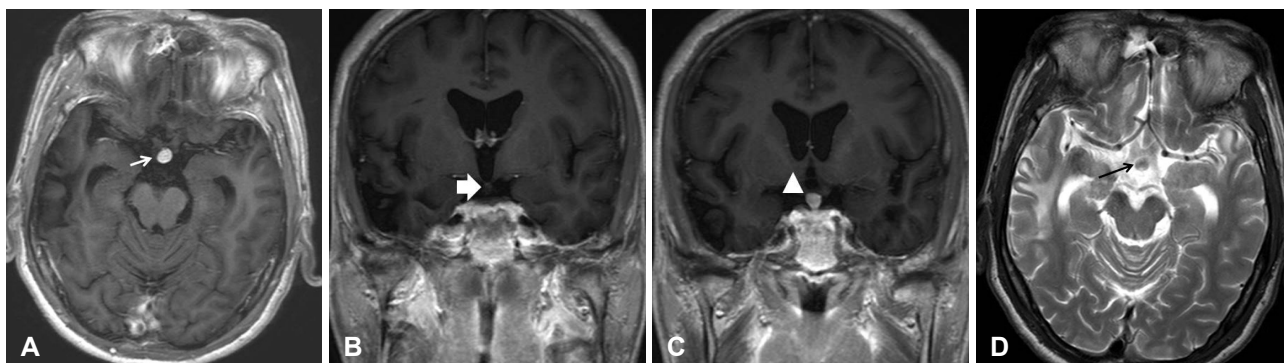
Preoperative magnetic resonance imaging findings. A: A preoperative T1-weighted gadolinium-enhanced axial image shows a homogeneously enhanced round mass (white arrow). B: A T1-weighted gadolinium-enhanced coronal image shows the pituitary stalk (white arrow). C: An anterior view of image B shows a round mass (white arrowhead). D: A T2-weighted axial image shows a mass (arrow) with low signal intensity.
